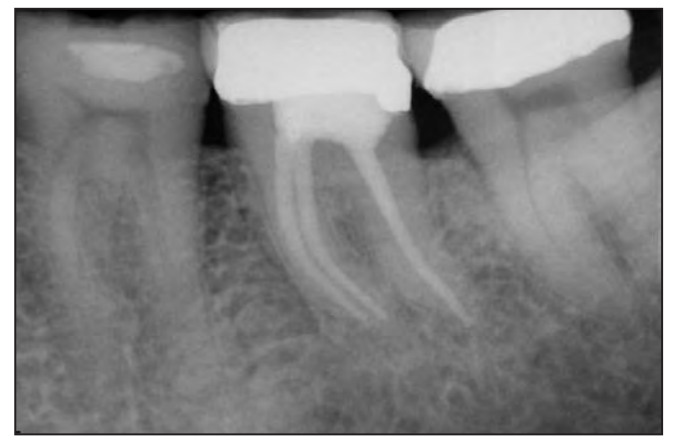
Final radiograph.
